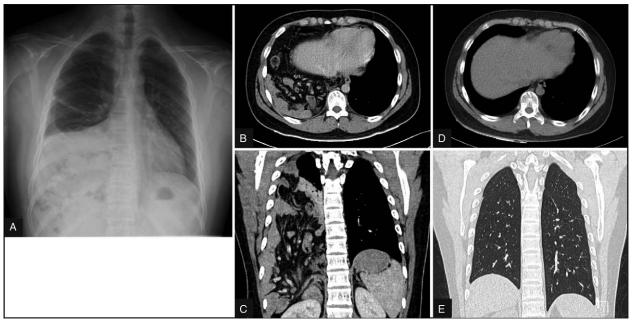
Chest radiograph and CT scan of chest pre-and post-operation. A: Chest radiograph showing atelectasis of right lung and elevated right diaphragm. B (axial) and C (coronal): CT scan confirmed the presence of pleuro-peritoneal hiatus hernia of right diaphragm. D (axial) and E (coronal): CT scan showed a normal manifestation of bilateral lungs after surgery. CT: Computed tomography.
